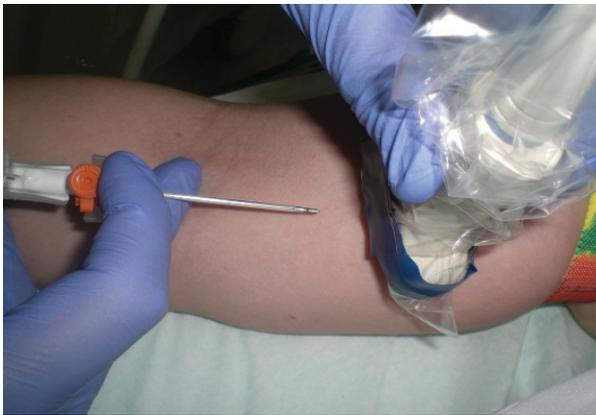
sonographically aided positioning of a Braunula with the linear array probe in the proximal medial upper arm: good emergency option in case of poor vein status in the emergency room or in the intensive care unit (there should always be an ultrasound device!)
